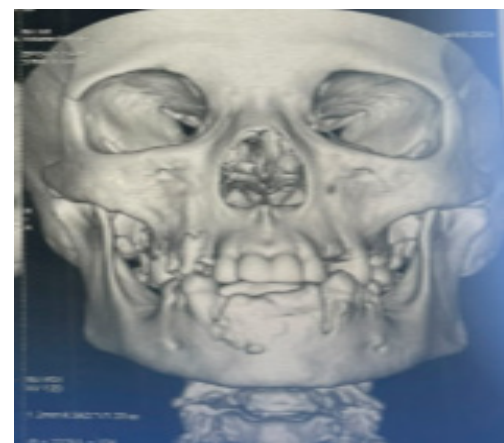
3D Volume Rendered CT Reconstruction.
